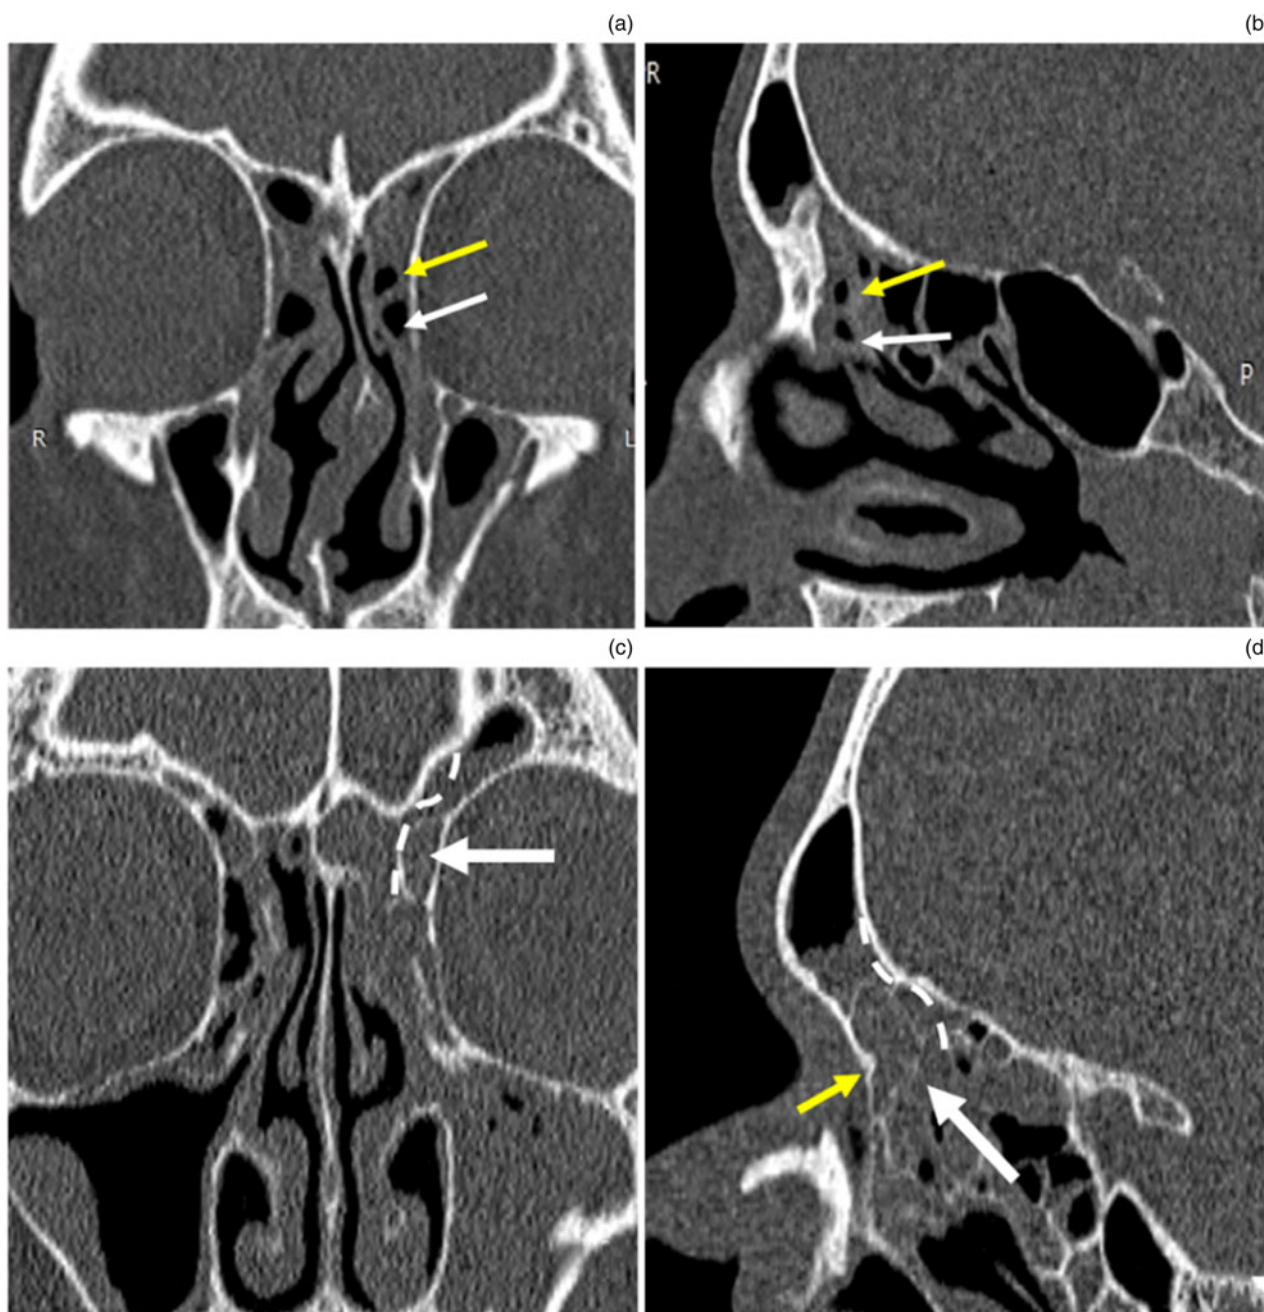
Anterior International Frontal Sinus Anatomy Classification cells. Non-contrast coronal (a) and sagittal (b) computed tomography (CT) images of the paranasal sinus, showing a left agger nasi cell (white arrow) and a left supra agger cell (yellow arrow) in a patient with bilateral frontal sinusitis. Non-contrast coronal (c) and sagittal (d) CT images of the paranasal sinus, showing a left supra agger frontal cell (white arrow) in a patient with bilateral frontal sinusitis, which is seen to pneumatise into the frontal sinus through the frontal ostium and to sit above the frontal beak (yellow arrow). The cell pushes the drainage pathway of the frontal sinus posteriorly and medially (white dotted line). R = right; L = left; P = posterior
